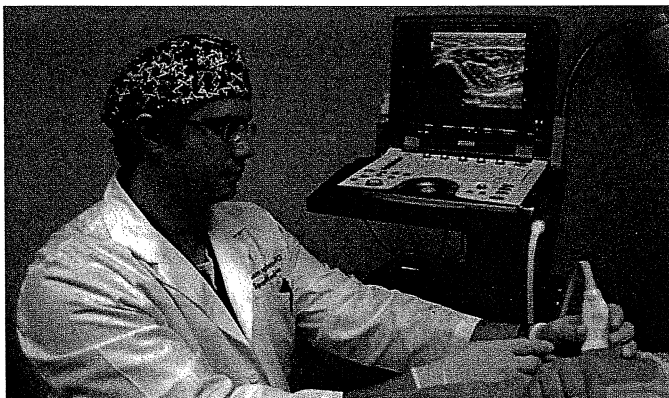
Dr. Weglein demonstrating ultrasound guided PRP.
